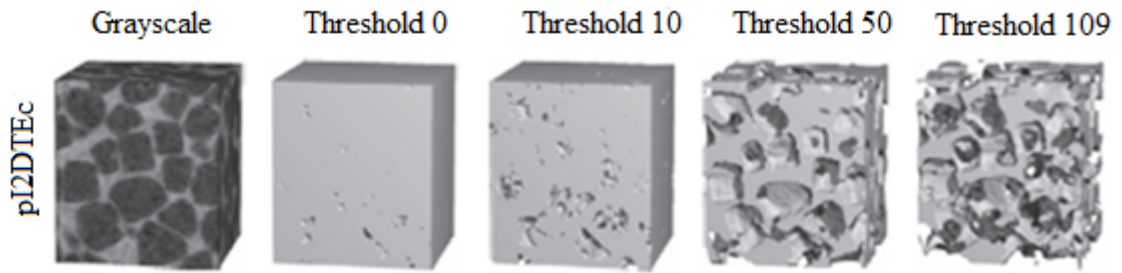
Iodinate analog of poly(desaminotyrosyl-tyrosine ethyl ester carbonate) (pI_2DTEc) scaffold 3D reconstruction at several different threshold values demonstrating the effect of applied threshold level to a visual view of CT image. [Modified 80]
